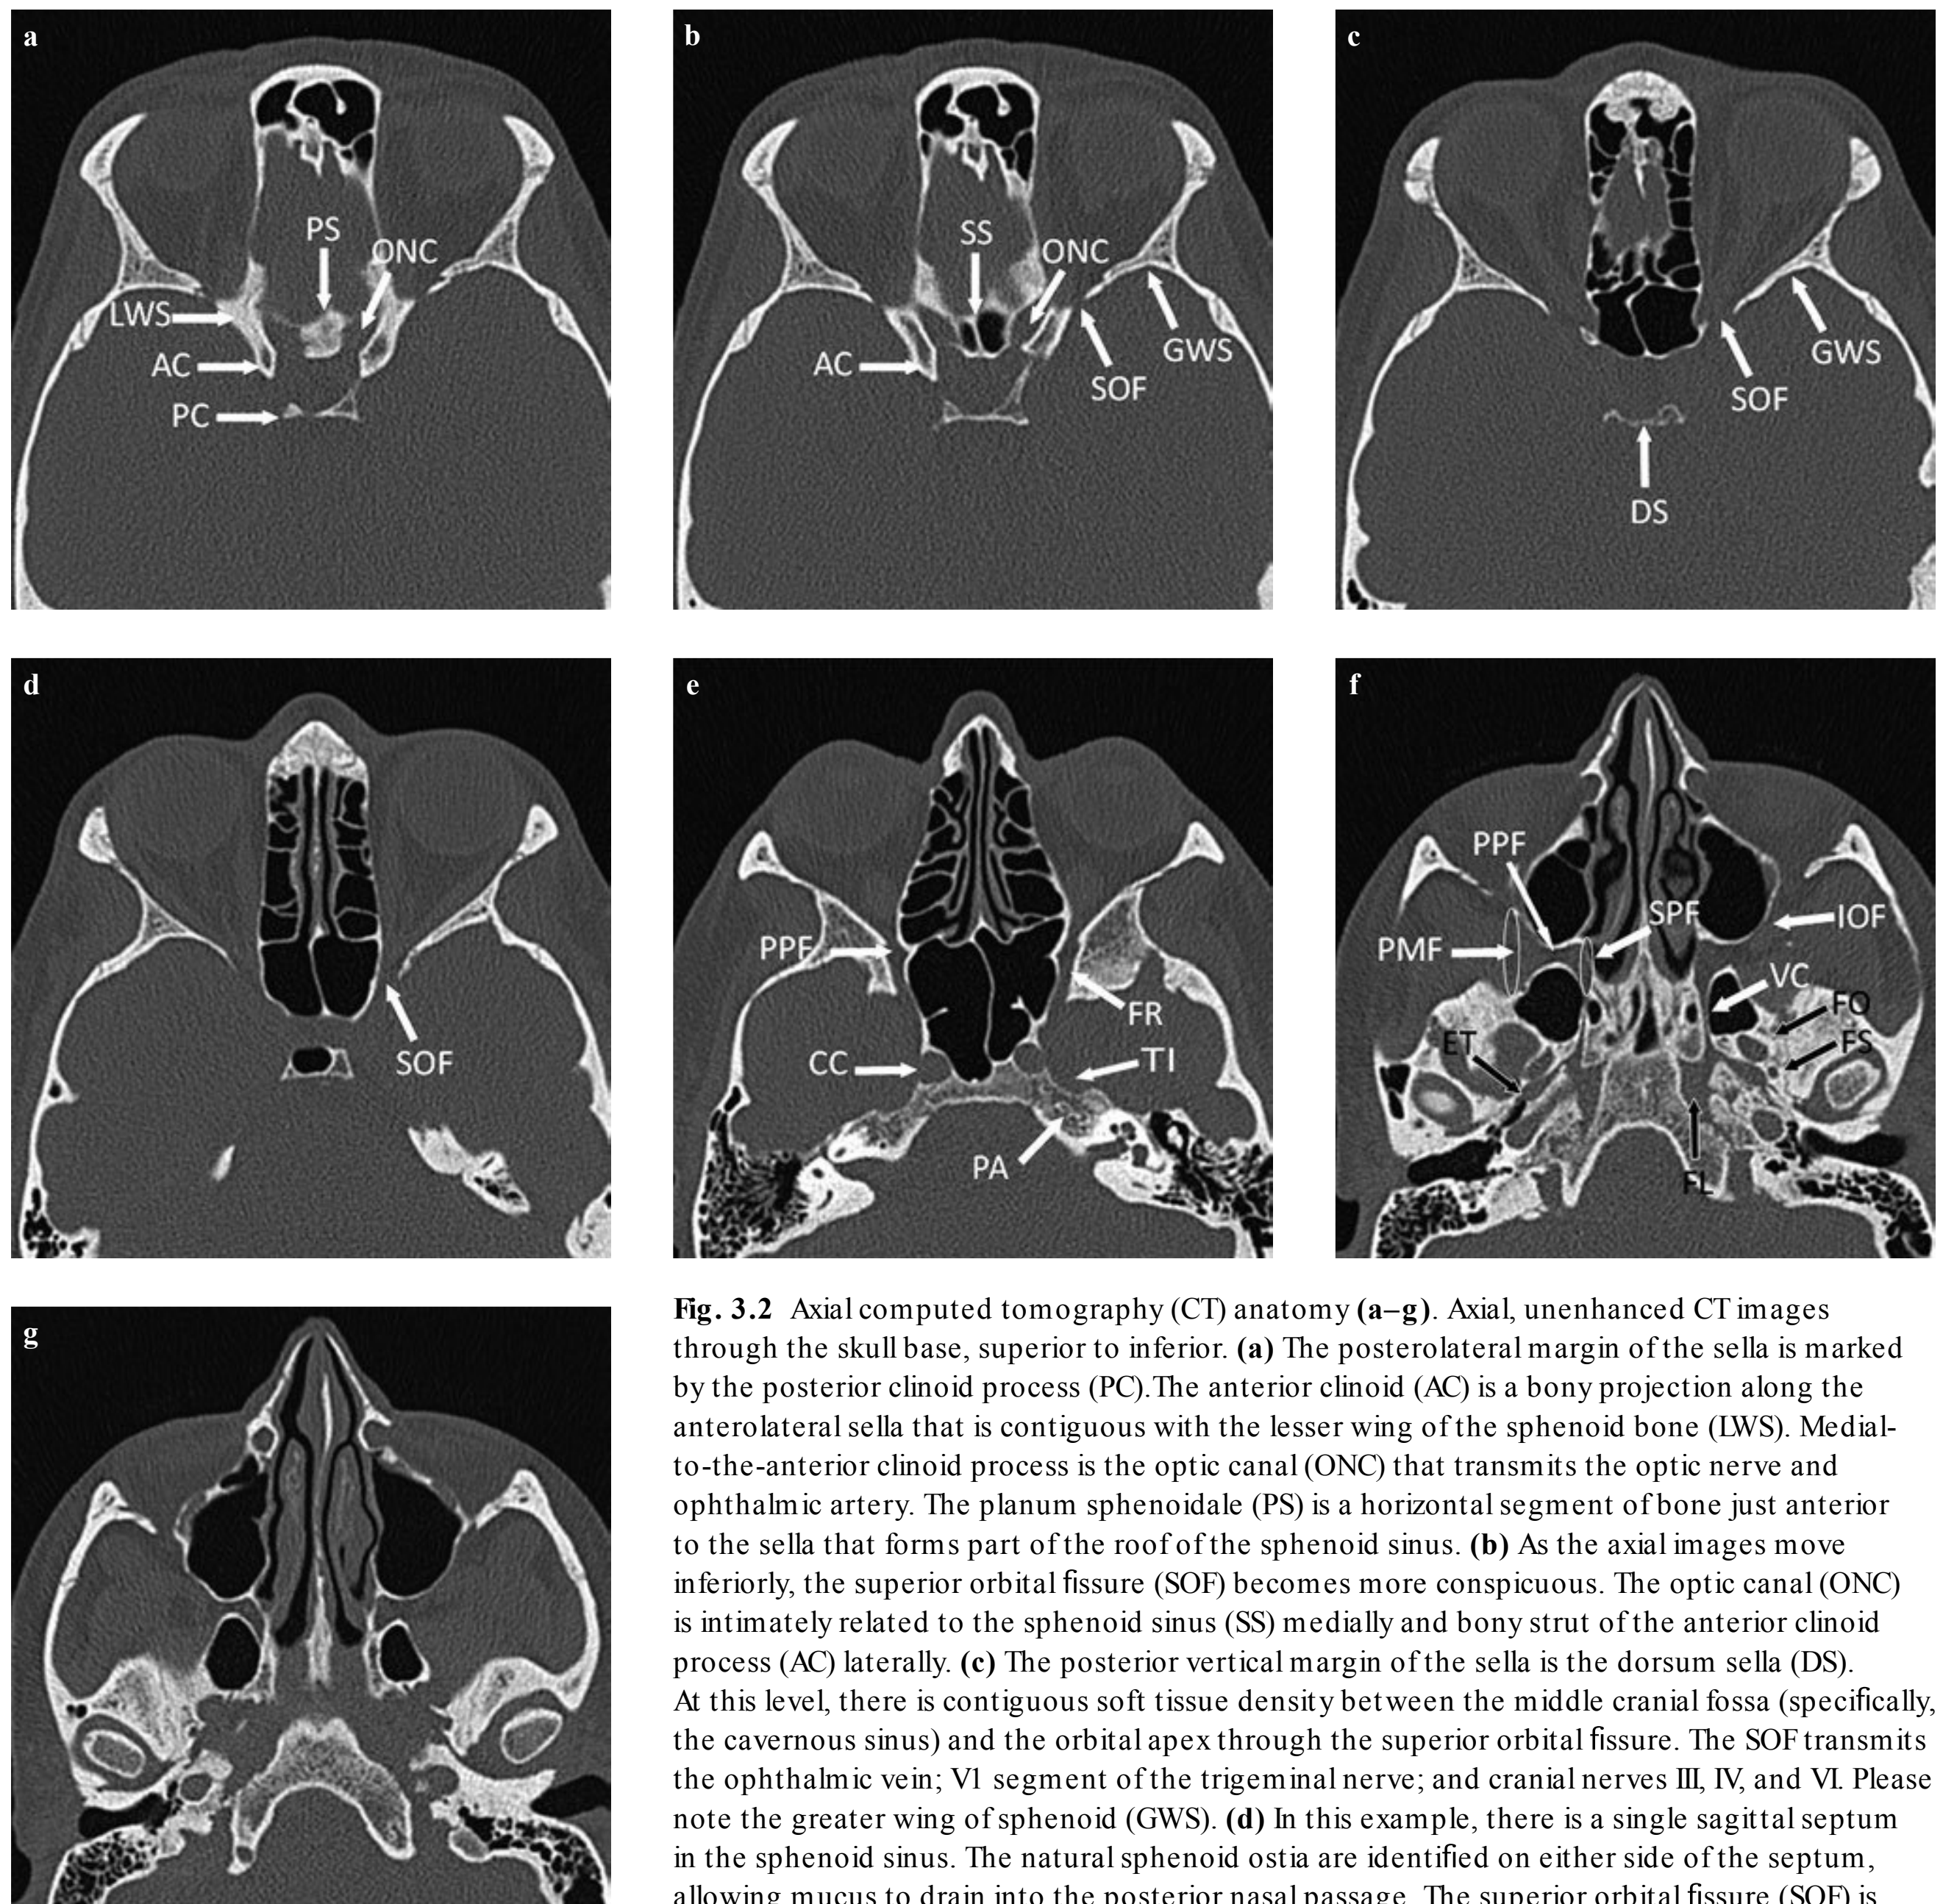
Axial computed tomography (CT) anatomy (a–g). Axial, unenhanced CT images through the skull base, superior to inferior. (a) The posterolateral margin of the sella is marked by the posterior clinoid process (PC). The anterior clinoid (AC) is a bony projection along the anterolateral sella that is contiguous with the lesser wing of the sphenoid bone (LWS). Medial-to-the-anterior clinoid process is the optic canal (ONC) that transmits the optic nerve and ophthalmic artery. The planum sphenoidale (PS) is a horizontal segment of bone just anterior to the sella that forms part of the roof of the sphenoid sinus. (b) As the axial images move inferiorly, the superior orbital fissure (SOF) becomes more conspicuous. The optic canal (ONC) is intimately related to the sphenoid sinus (SS) medially and bony strut of the anterior clinoid process (AC) laterally. (c) The posterior vertical margin of the sella is the dorsum sella (DS). At this level, there is contiguous soft tissue density between the middle cranial fossa (specifically, the cavernous sinus) and the orbital apex through the superior orbital fissure. The SOF transmits the ophthalmic vein; V1 segment of the trigeminal nerve; and cranial nerves III, IV, and VI. Please note the greater wing of sphenoid (GWS). (d) In this example, there is a single sagittal septum in the sphenoid sinus. The natural sphenoid ostia are identified on either side of the septum, allowing mucus to drain into the posterior nasal passage. The superior orbital fissure (SOF) is noted (arrow). (e) At this level, the petrous apex (PA) can be seen as a pyramidal shaped, medial extension of the temporal bone. Along the superior and medial margin of the petrous apex is a shallow concavity, the trigeminal impression (TI). The medial opening of the carotid canal (CC) is seen, separated from the sphenoid sinus by thin cortical bone. The foramen rotundum (FR) opens into the upper recess of the pterygopalatine fossa (PPF). (f) The foramen lacerum (FL) is a triangular shaped, horizontal layer of cartilage between the clivus and petrous apex. The eustachian tube (ET) is seen just lateral to the carotid canal, extending lateral to medial and superior to inferior. The foramen ovale (FO) and foramen spinosum (FS) are seen in the lateral sphenoid bone. The vidian canal (VC) contains the vidian nerve and travels from a point near the foramen lacerum forward to the pterygopalatine fossa (PPF). The PPF connects with the masticator space laterally through the pterygomaxillary fissure (PMF, large oval) and medially through the sphenopalatine foramen (SPF, small oval) with the nasal cavity. The infraorbital nerve passes from the PPF into the inferior orbital fissure (IOF) on its way to the cheek. (g) At this level, soft tissues that form the roof of the nasopharynx begin to show up ventral to the clivus. Note that these soft tissues are directly contiguous with the region of the eustachian tube and foramen lacerum.
